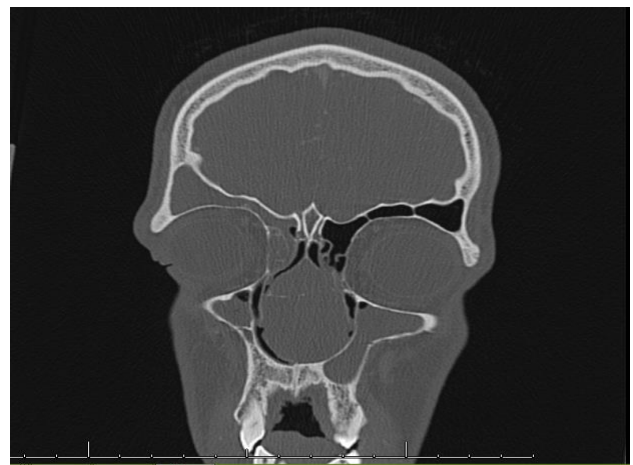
CT scan coronal view showing a mass within the nasal septum.
